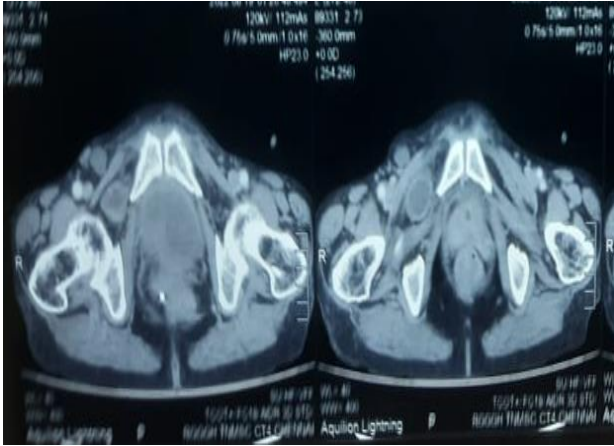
Pre-operative CT-abdomen.
